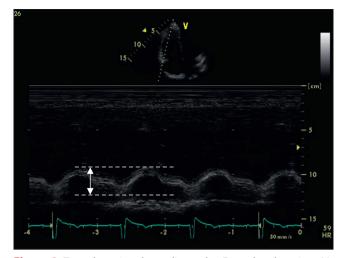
Transthoracic echocardiography. Four-chamber view. Mmode. Tricuspid annular plain systolic excoursion (TAPSE) 16 mm (white arrow)
